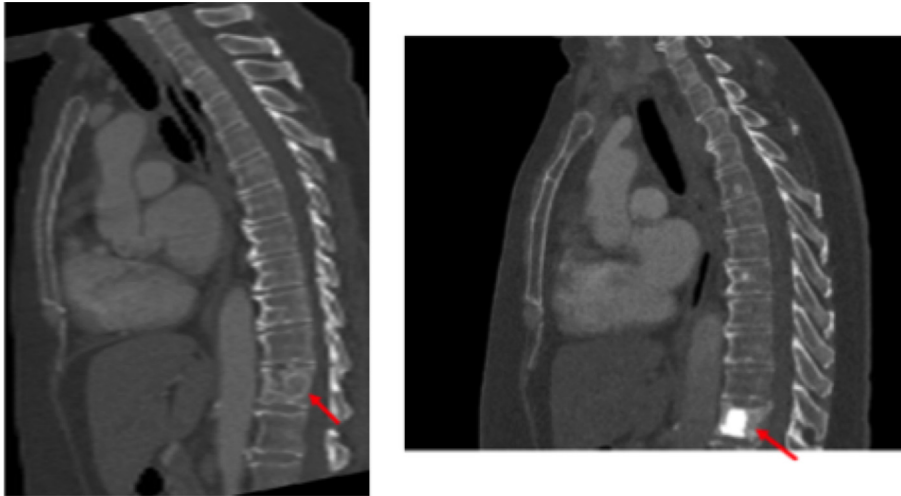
CT scans pre and post-kyphoplasty.
